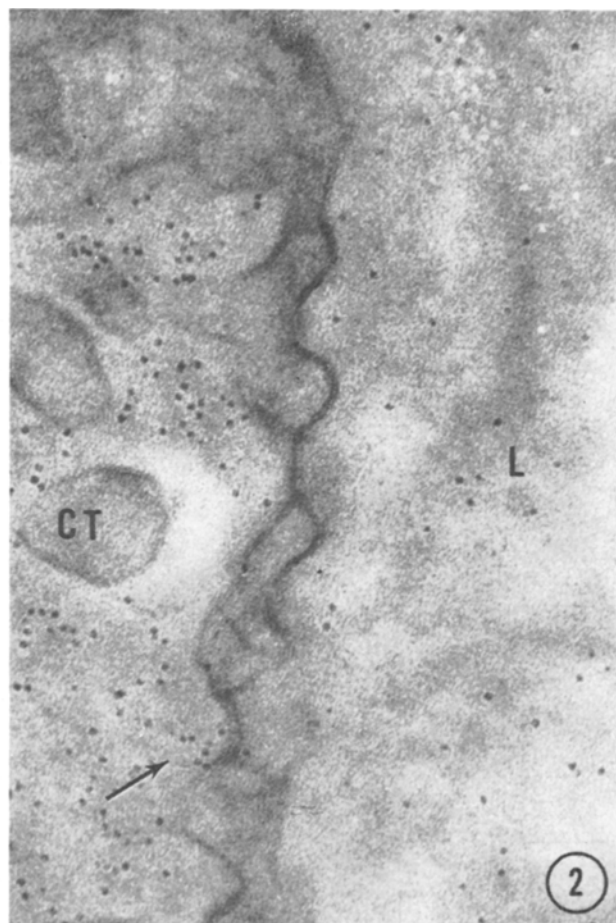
Venous limb of a capillary in the medulla. Ferritin was injected into the connective tissue (CT) 8 min previously and is passing into the lumen (L). Some molecules may be seen in a fenestra, very close to its diaphragm (arrow). Another fenestra with a diaphragm is also visible.  $\times 150,000$ .
